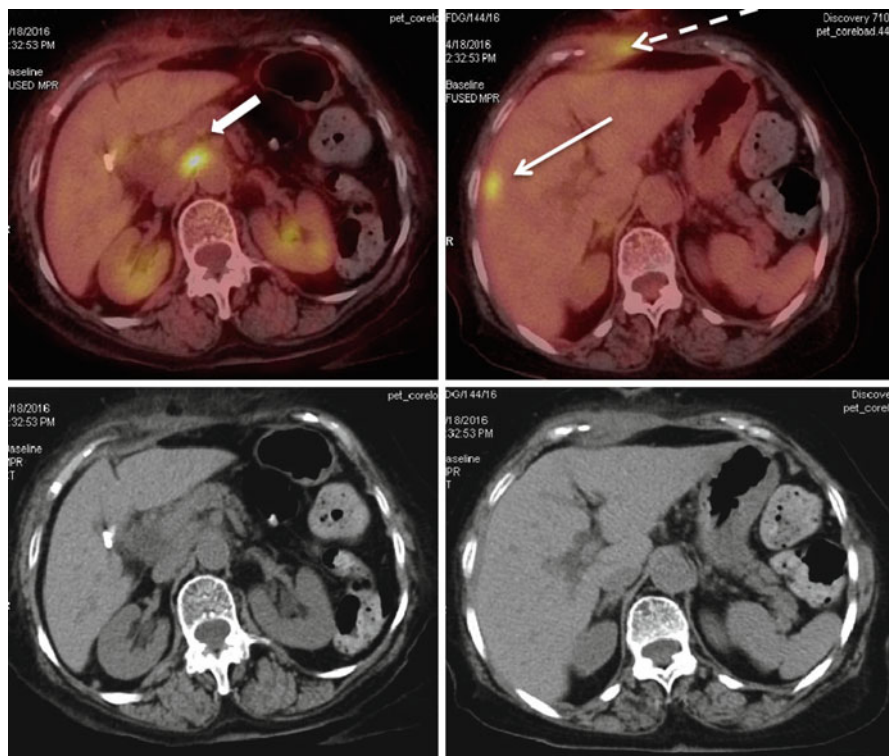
A 73-year-old lady with gall bladder carcinoma following cholecystectomy. PET-CT (*upper row*) and CT (*lower row*) revealed FDG uptake at the port site (*dashed arrow*), corresponding to the soft tissue thickening seen in CT with FDG avid liver (*straight arrow*) and peripancreatic lymph nodes (*block arrow*)
